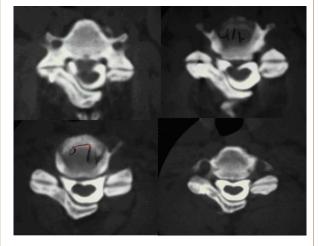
Computed tomography of Figure 2 case at multiple levels shows increase in anteroposterior diameter after suture anchor laminoplasty.
